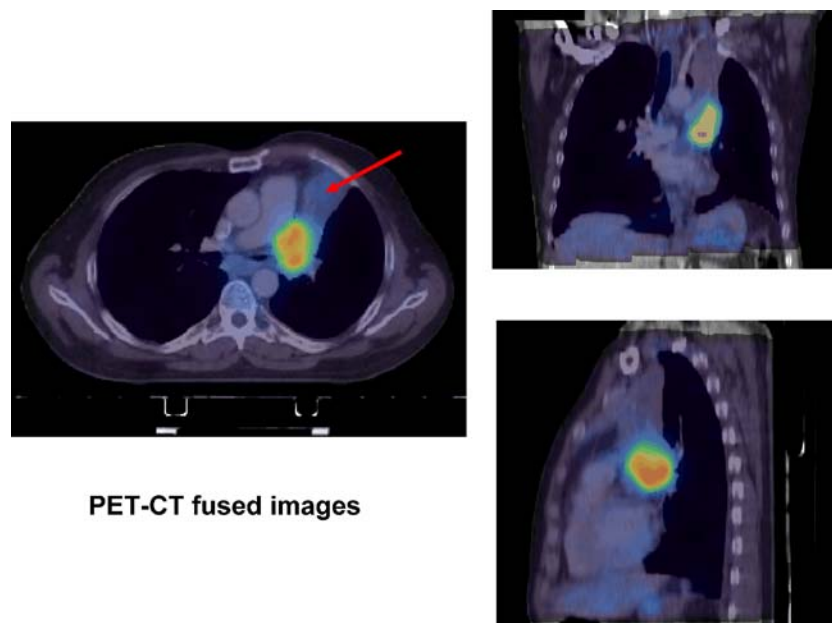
Co-registration PET and CT data (obtained from separate PET and CT devices) performed on a Hermes workstation, using a normalized mutual information algorithm. The axial, coronal and sagittal images belong to a non-small-cell lung cancer patient with atelectasia of the left upper lobe (shown by the *arrow*), which was not
